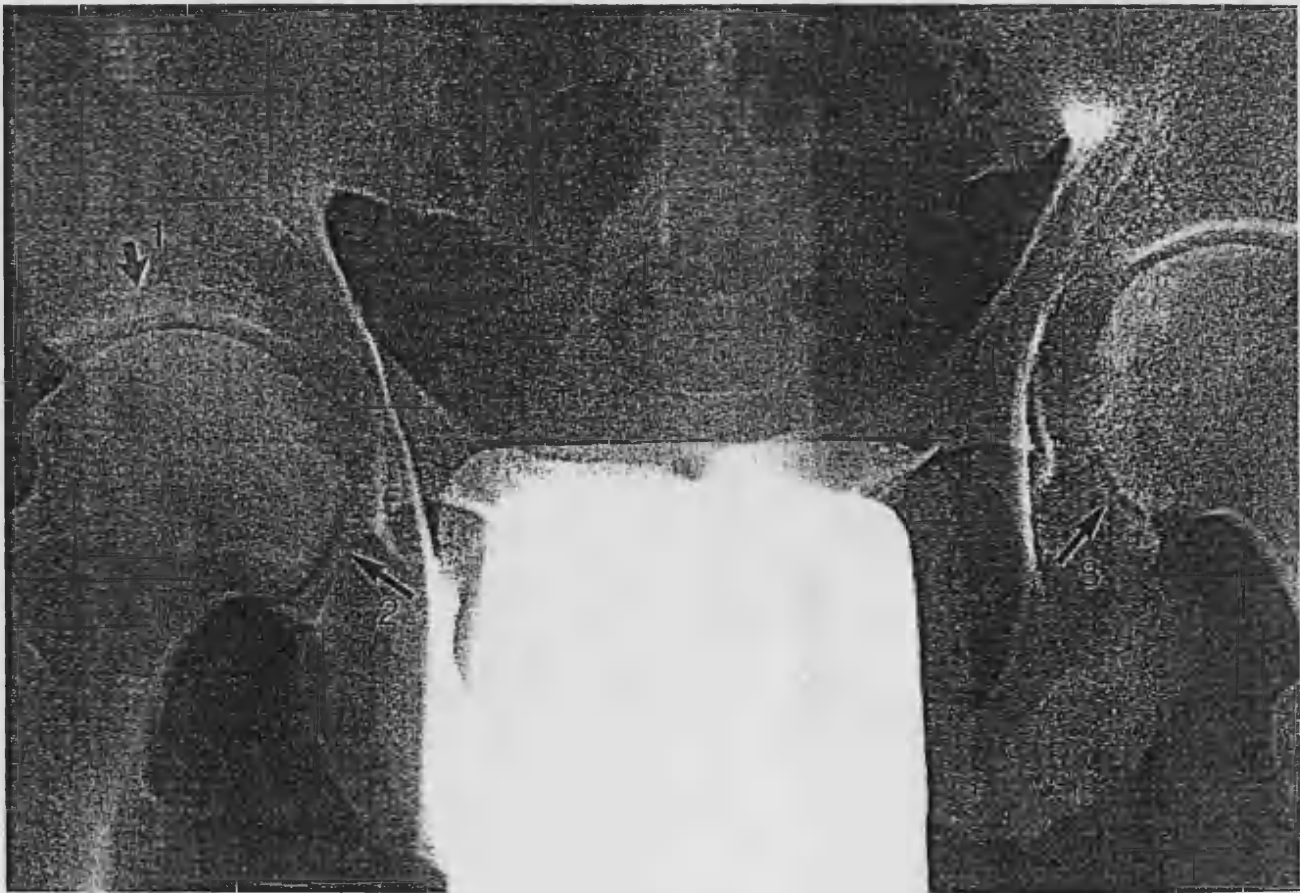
These pelvic radiographs are of the same AS patient. The first was taken when he was age 25 and had had disease for 5 years. Shown here: a BASRI-h score of grade 2 (mild disease) for the right hip with erosions (arrow 1), osteophytes and focal joint space narrowing (arrow 2). BASRI-hip score for the left hip is grade 1 (suspicious disease) with focal joint space narrowing only (arrow 3).
